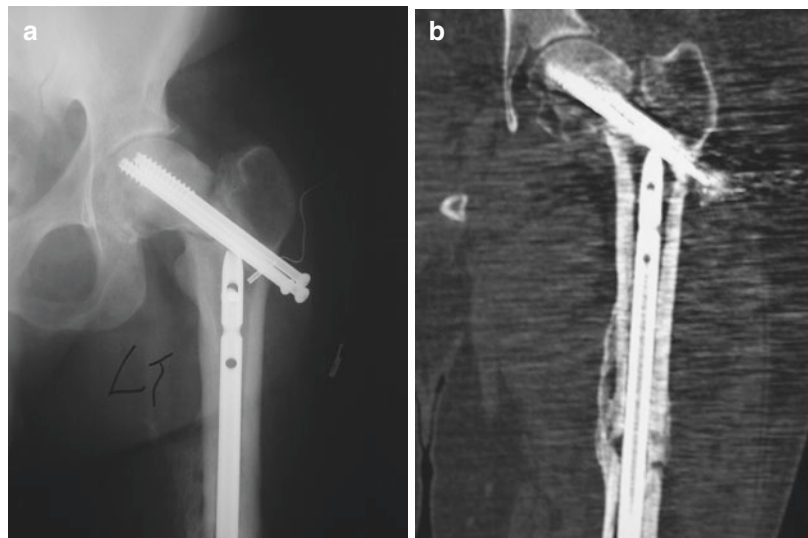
A 38-year-old male who sustained an ipsilateral femoral neck and shaft fracture. (a) Anteroposterior (AP) radiograph at 4 months suggests nonunion. (b) A reconstructed CT image demonstrating a clear femoral neck nonunion
